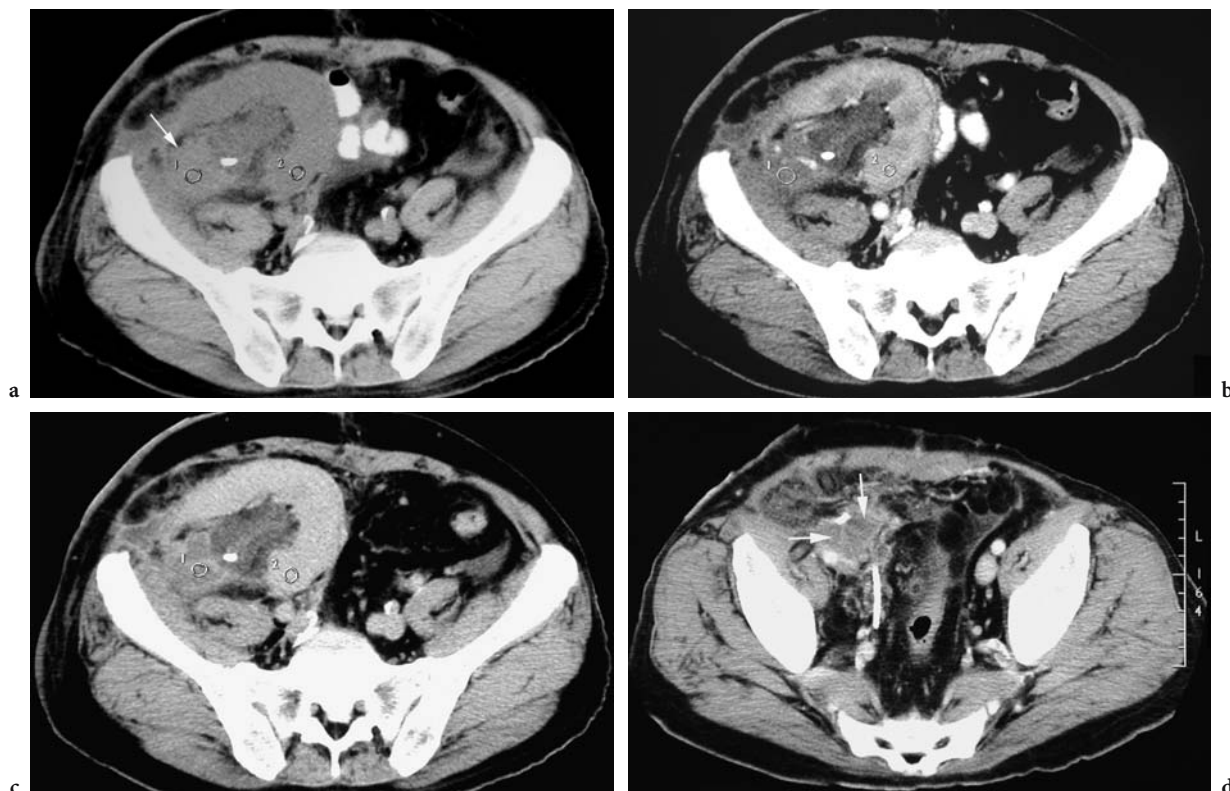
Post-transplantation lymphoproliferative disorder arising from the renal allograft in a 49-year-old woman. a Axial unenhanced CT scan through the pelvis shows a soft tissue thickening (*arrow*) at the renal pedicle. Note a JJ drainage stent at the pelviureteric junction. b Axial CT scan at the arterial phase of contrast administration show minimal contrast enhancement of the renal pedicle mass, which is hypodense relative to normally enhancing renal tissue and remains hypodense on c the venous phase of contrast administration. d The mass has extended inferiorly along and surrounding the ureter (*arrows*).
